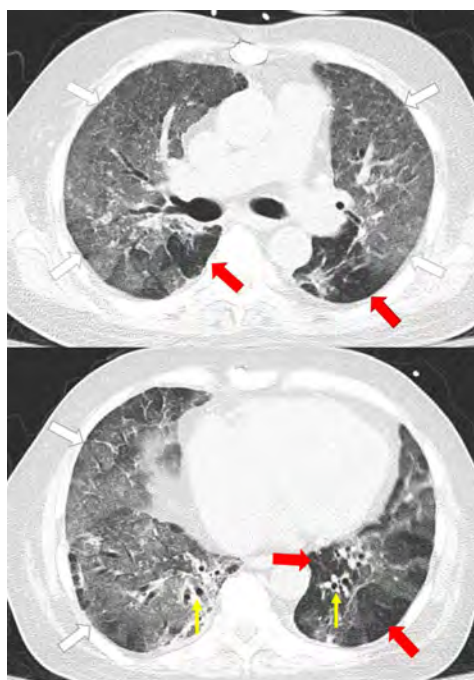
High-resolution CT scan of the chest showing features of BO: mosaic attenuation (red arrows), bronchiectasis and airway thickening (yellow arrows) diffuse ground-glass opacity (white arrows).
